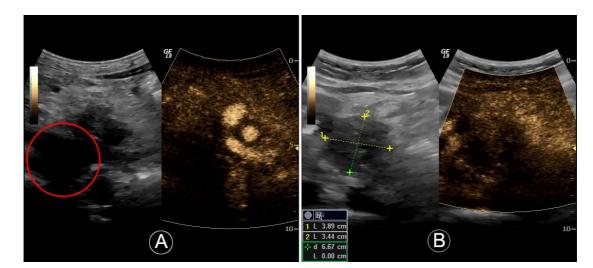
Images captured using customised sonoporation settings using a clinical ultrasound scanner. The dense vasculature in early arterial phase to the right of the main tumour (circled in red) can be seen in panel A. Panel B shows the dimensions of the main tumour, indicated by lines 1 and 2, using the sonoporation settings.
